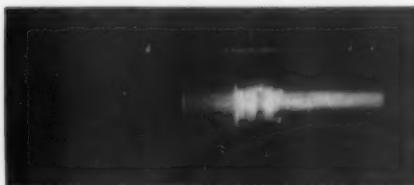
Photographic demonstration of uniformity of ultrasound field by striation method.
